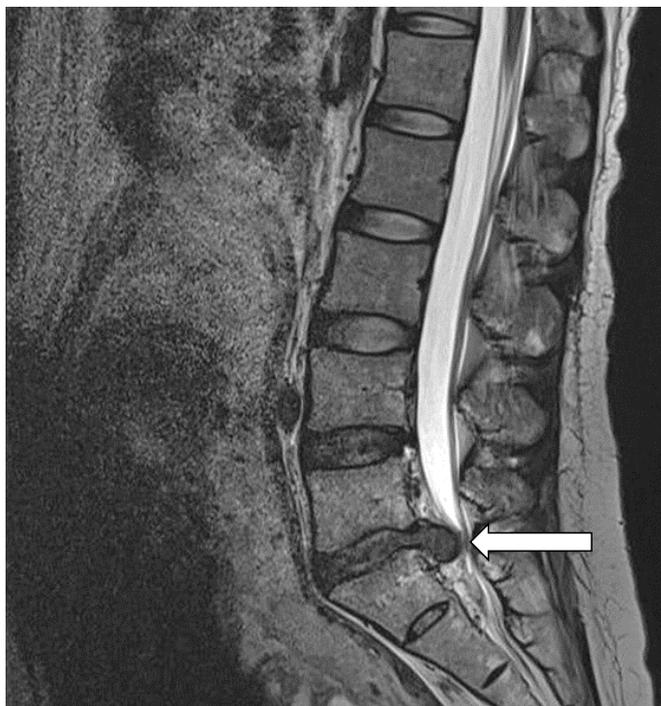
Sagittal T2-weighted magnetic resonance image showing herniated nucleus pulposus at the L5–S1 level (arrow) compromising the thecal sac during pregnancy.
